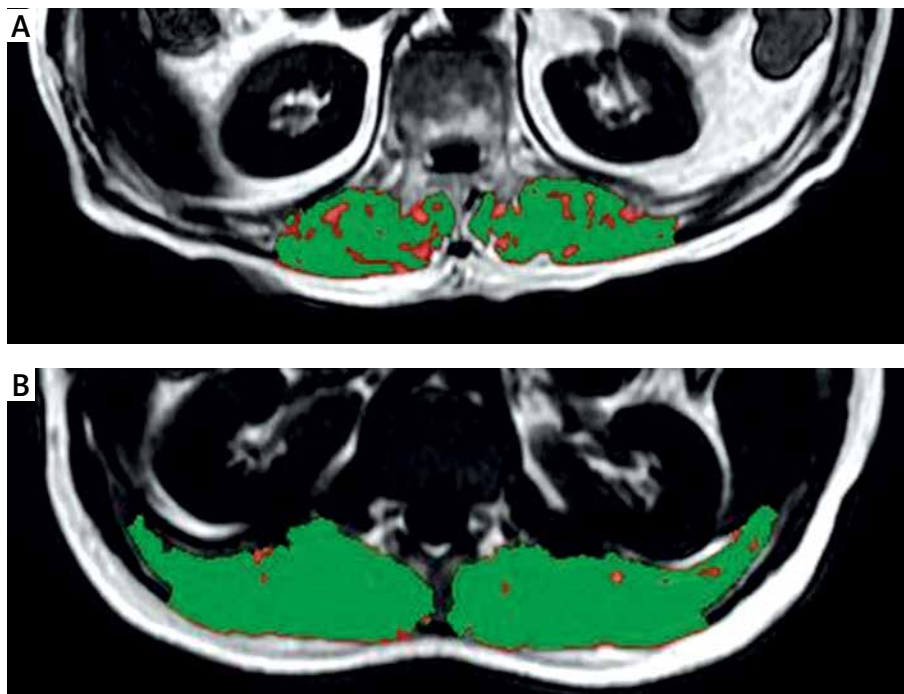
Skeletal muscle measurements of bilateral erector spinae muscles via cross-sectional images (fat-only images derived from dual-echo, T1-weighted, 3D gradient-recalled-echo sequences) on the level of the radix of the superior mesenteric artery. Individual with low fat-free muscle index showed FFMA (green areas in Figure 2 A) of 26.85 cm² and FFMI of 9.29 cm²/m². Individual with high fat-free muscle index, showed FFMA (green areas in Figure 2 B) of 53.76 cm² and FFMI of 17.16 cm²/m²
